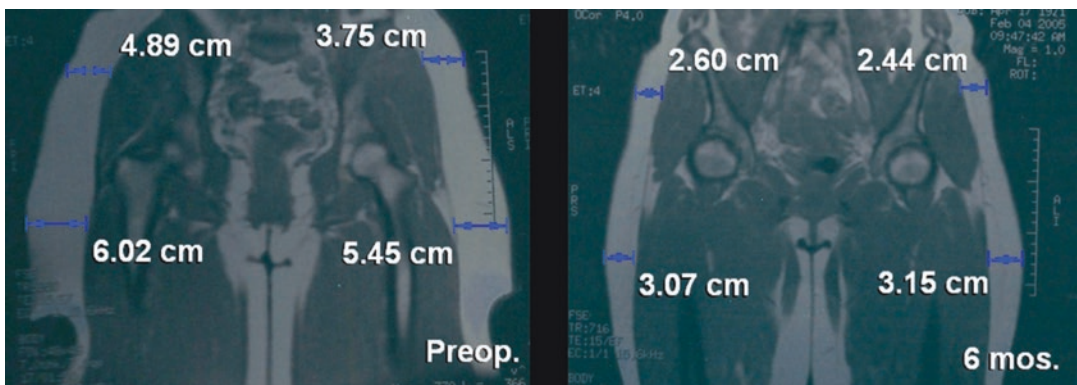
Coronal MRI scans of a 33-year-old woman with a BMI of 27.5 kg/m² (*left*) before and (*right*) 6 months after ultrasonic liposuction of the lower body, arms, and axillae. The total aspirate volume was 3000 cc. The reduction in subcutaneous fat is indicated at the flanks and outer thighs [Reprinted from Swanson E. Prospective
